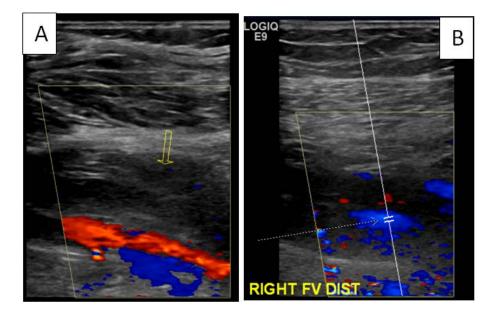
Venous doppler ultrasound of the right lower extremity showed deep venous thrombosis of the right popliteal vein (A) and involving the right femoral vein (B)
